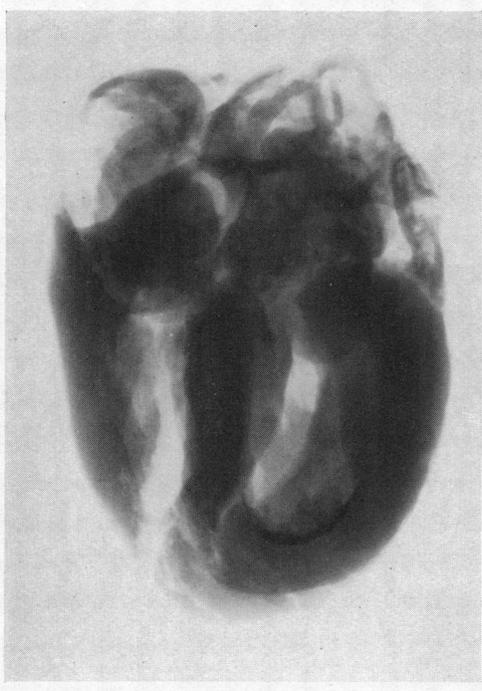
X-Ray of isolated heart to show plate of calcium at the apex of the left ventricle (Case 19).
